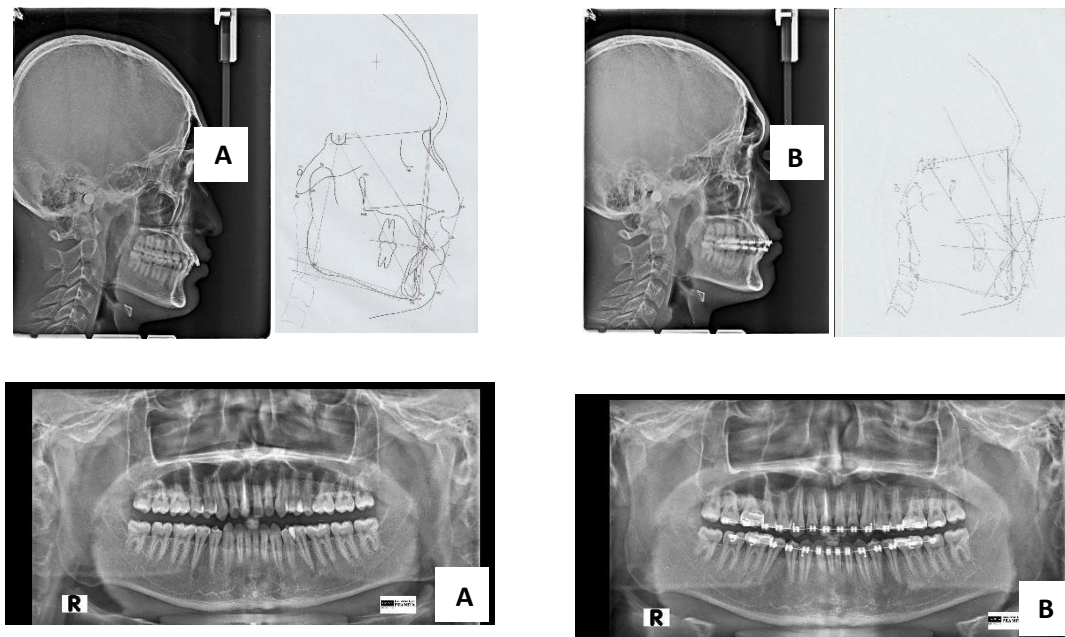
A. Pre-treatment lateral cephalometric tracing and panoramic radiograph; B. Post-treatment lateral cephalometric tracing and panoramic radiograph.
